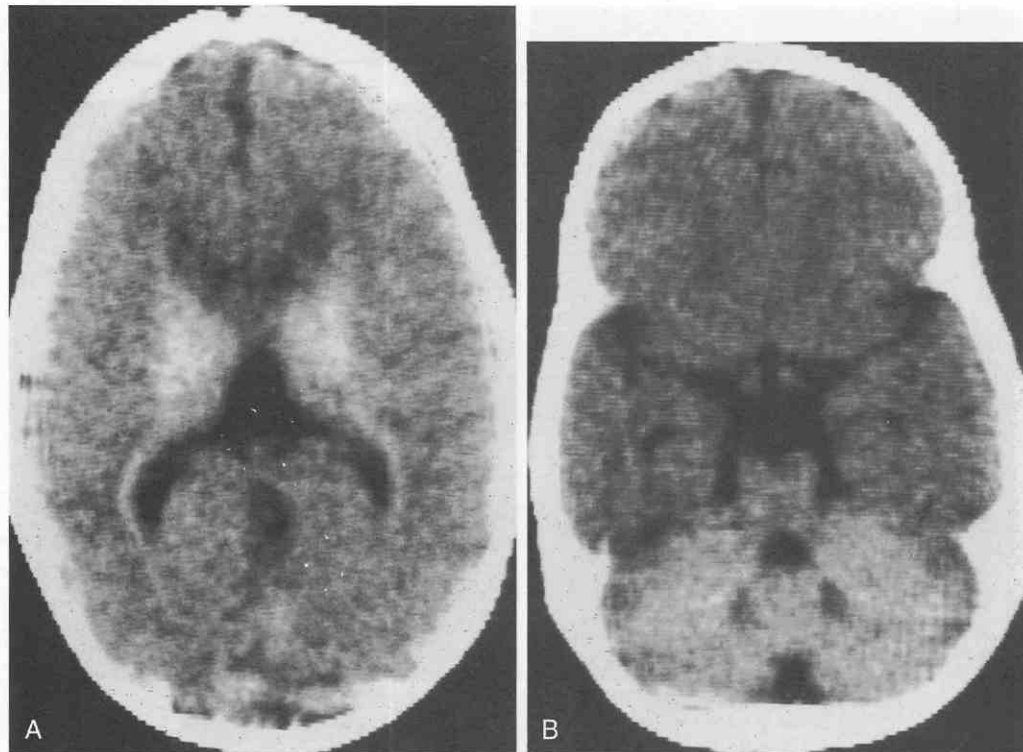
Globoid cell leukodystrophy (GLD), or Krabbe's disease, in a 3-month-old girl. Two representative CT sections disclose relative density of the cerebellum, thalami, and periventricular regions. Attenuation measurements of these regions confirm a slightly higher density than in the normal cortex. The remainder of the brain shows uniform attenuation without white matter lucency. This is a representative appearance for early GLD, with later scans usually showing minimal white matter changes but severe cortical atrophy.
